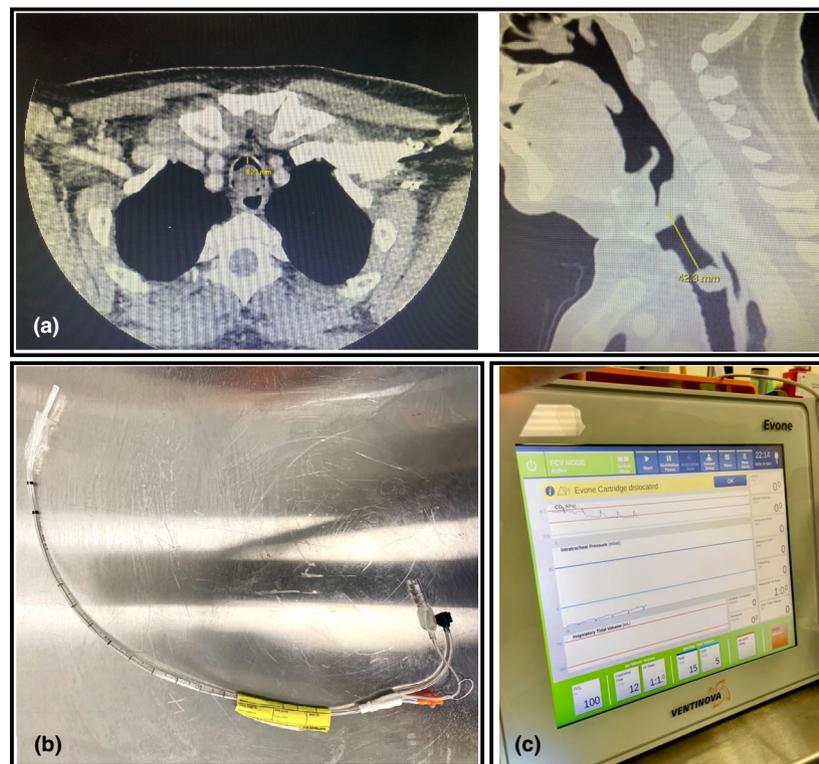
(a) Axial (left) and sagittal (right) computed tomography imaging of the patient's trachea; (b) Tritube; and (c) Evone ventilator showing 'cartridge error' message.
